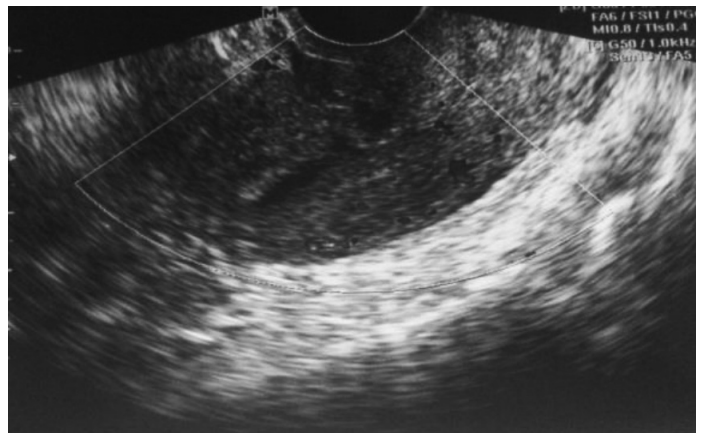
Transvaginal Sonography at 5th post-operative day. The Previously noted AV malformation was not appreciated.
